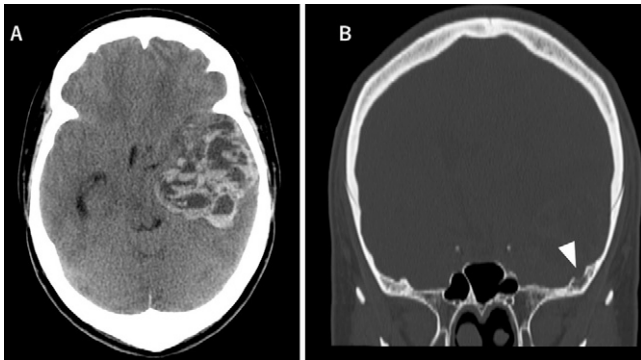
A: Axial CT scan showed a 50-mm cystic lesion with multiple fluid levels arising from the left temporal bone. B: Coronal CT scan showed erosion of the inner table of the temporal bone (*arrowhead*).
